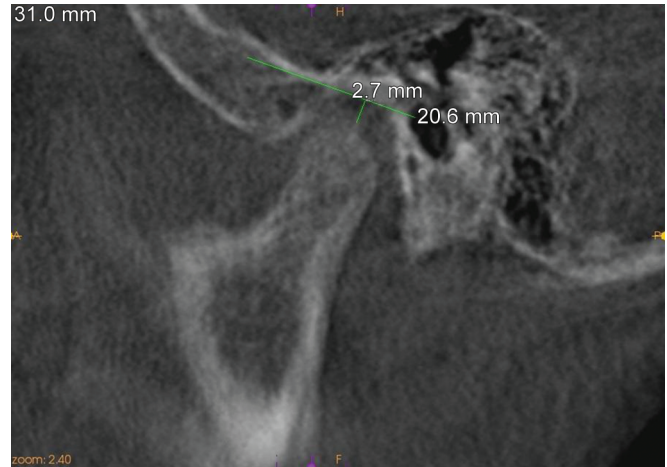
Cone-beam computed tomography (CBCT) scan of articular space middle pretreatment
